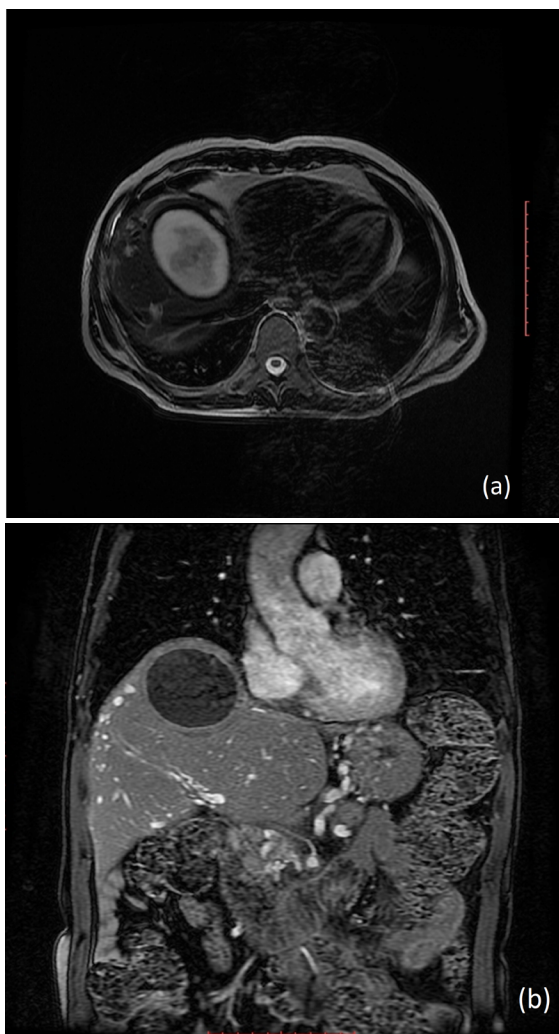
Abscess in the VIII liver segment measuring 8.2 x 6.0 x 5.2 cm shown in (a) axial T2-weighted and (b) Fat-saturated post gadolinium coronal T1-weighted Abdominal MRI.
